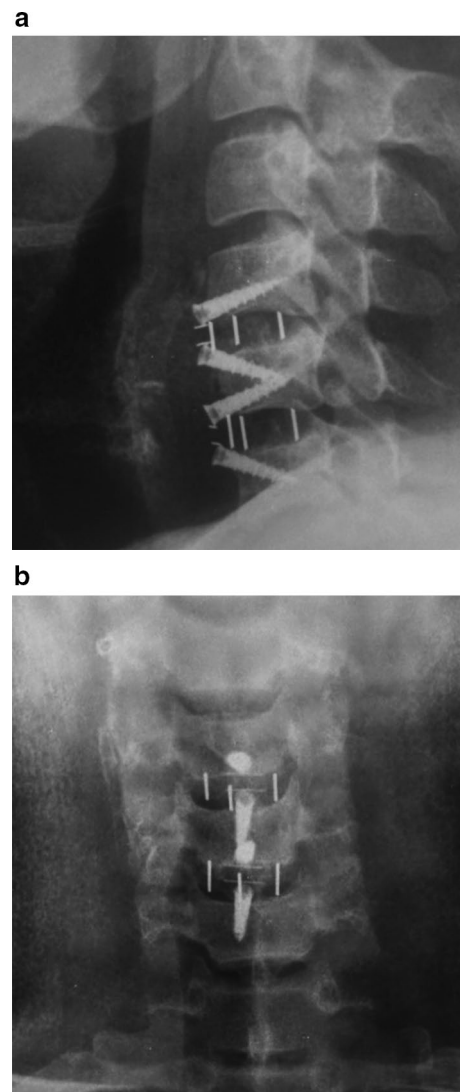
a Post-operative lateral radiograph. b Post-operative AP radiograph
